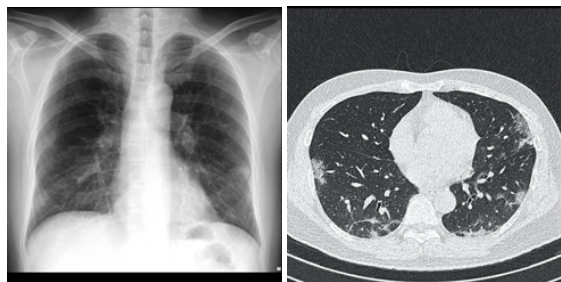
Radiological findings of the first patient. (a). CXR, vague bilateral peripheral ground-glass opacity infiltrates; (b). Chest CT (transverse), bilateral peripheral ground-glass opacity with interlobular septal thickening.
